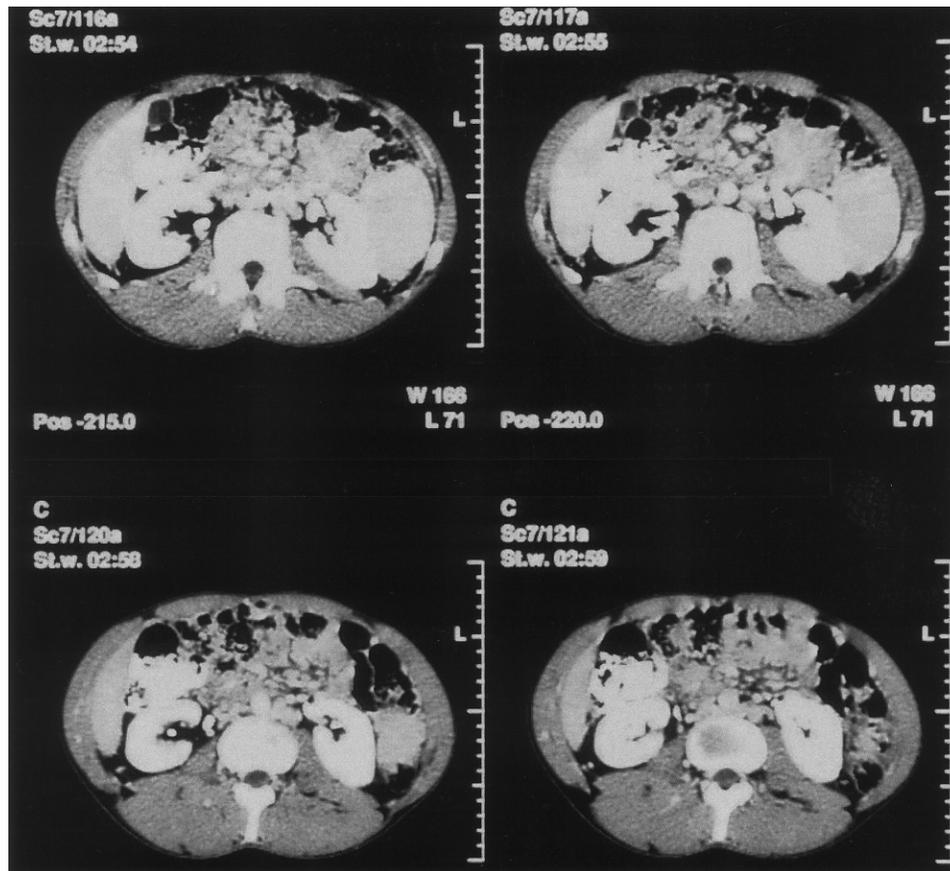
Axial CT of the abdomen during *Paracoccidioides brasiliensis* disseminated infection. It is important to note the extensive intra-abdominal lymphadenomegaly.
